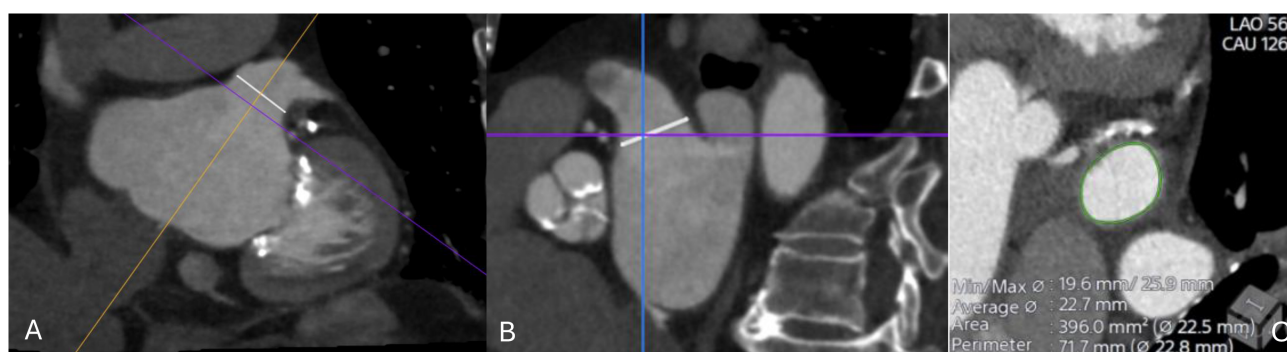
CT imaging assessment of the left atrial appendage (LAA) prior to percutaneous closure. (A) Oblique multiplanar reconstruction demonstrating the ostium of the LAA (white line), aligned along the true anatomical axis. (B) Orthogonal cross-sectional view showing the same ostial measurement (white line) in the perpendicular plane. (C) Cross-sectional reconstruction at the level of the ostium with automated contouring (green) and derived measurements of minimal and maximal diameters, average diameter, area, and perimeter (22.5–22.8 mm). These values are used for device sizing and procedural planning.
